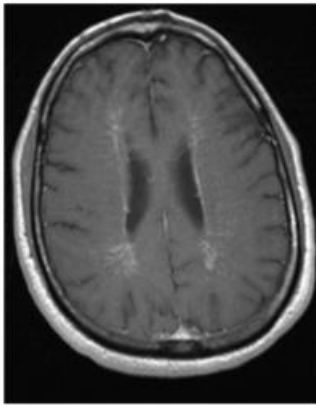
T1-weighted MRI brain with contrast demonstrates curvilinear periventricular enhancement in a perivascular distribution.
